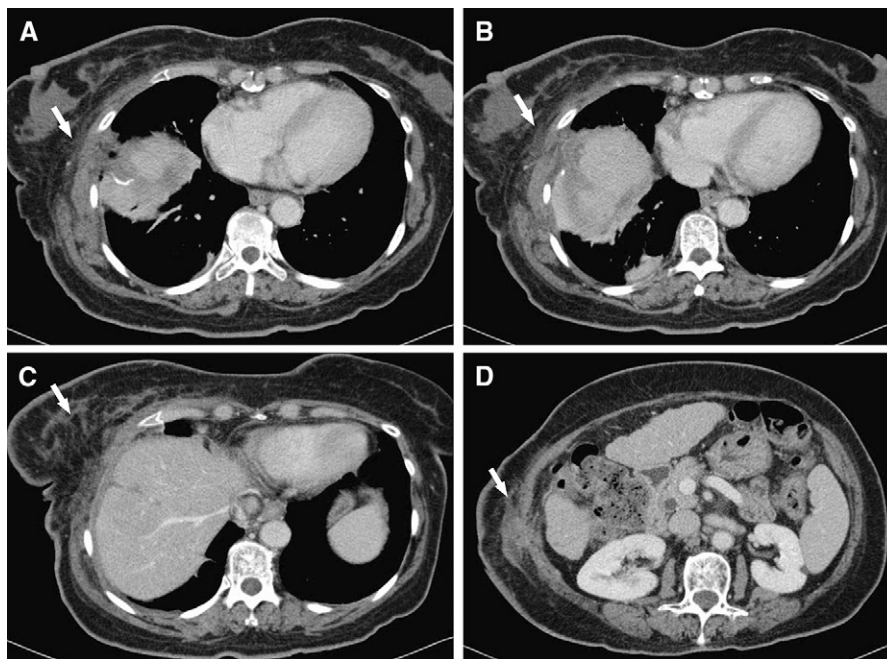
After needle biopsy of pathologically proven hepatocellular carcinoma (HCC), resulting in tumour tract seeding. Contrast-enhanced transaxial computed tomographic images on the portal venous phase, demonstrating soft-tissue changes within the right pleura (A), right hemithorax (B), musculature (C), and subcutaneous tissues (D) after needle biopsy of a liver mass, which was proven to be HCC on pathology. These changes, indicated by arrows, represent needle tumour tract seeding, which resulted in a significantly different surgical approach with wider resection margins.
